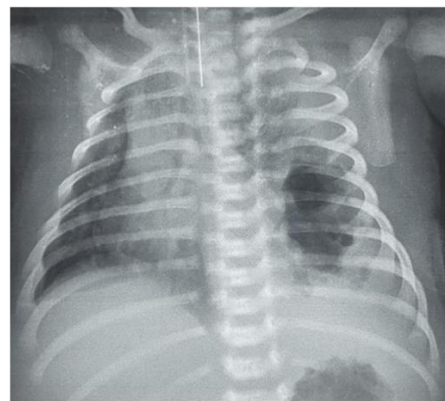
Radiographic image for Case 5.
